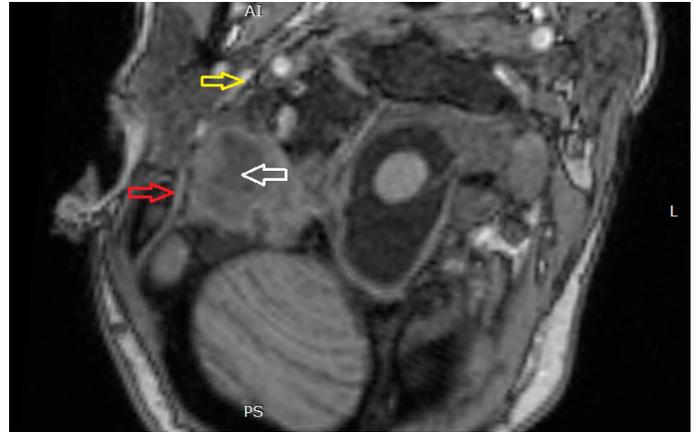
MRI – transversal cross-section. The arrows show: red color – insertion of the posterior belly of the right two-bellied muscle; yellow – right occipital artery; white – abscess cavity.
